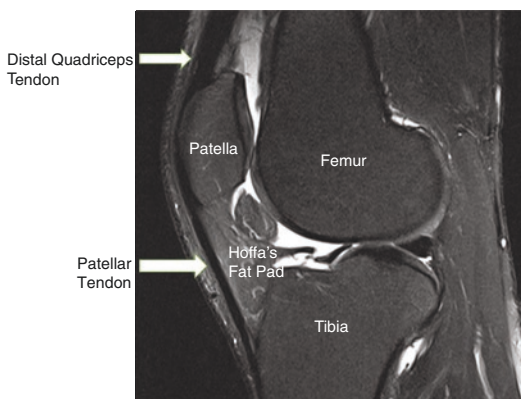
MRI – normal quadriceps tendon
